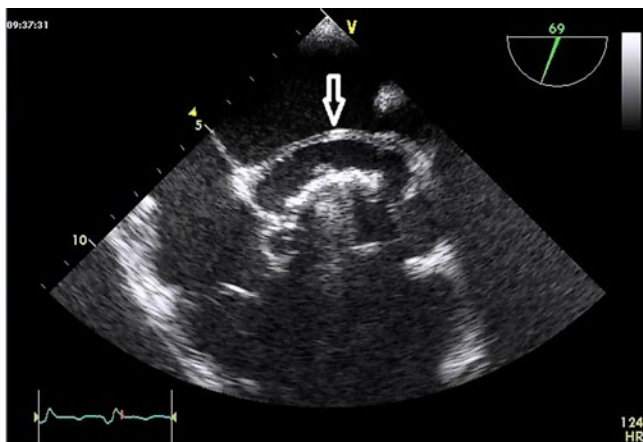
▲ Transesophageal echocardiographic view of a pseudoaneurysm (arrow)
